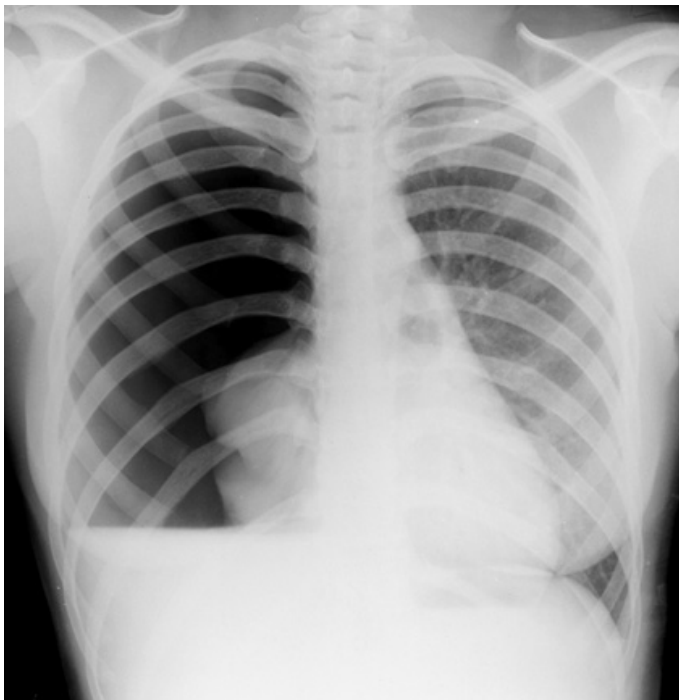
Chest x-ray showing a large right pneumothorax
